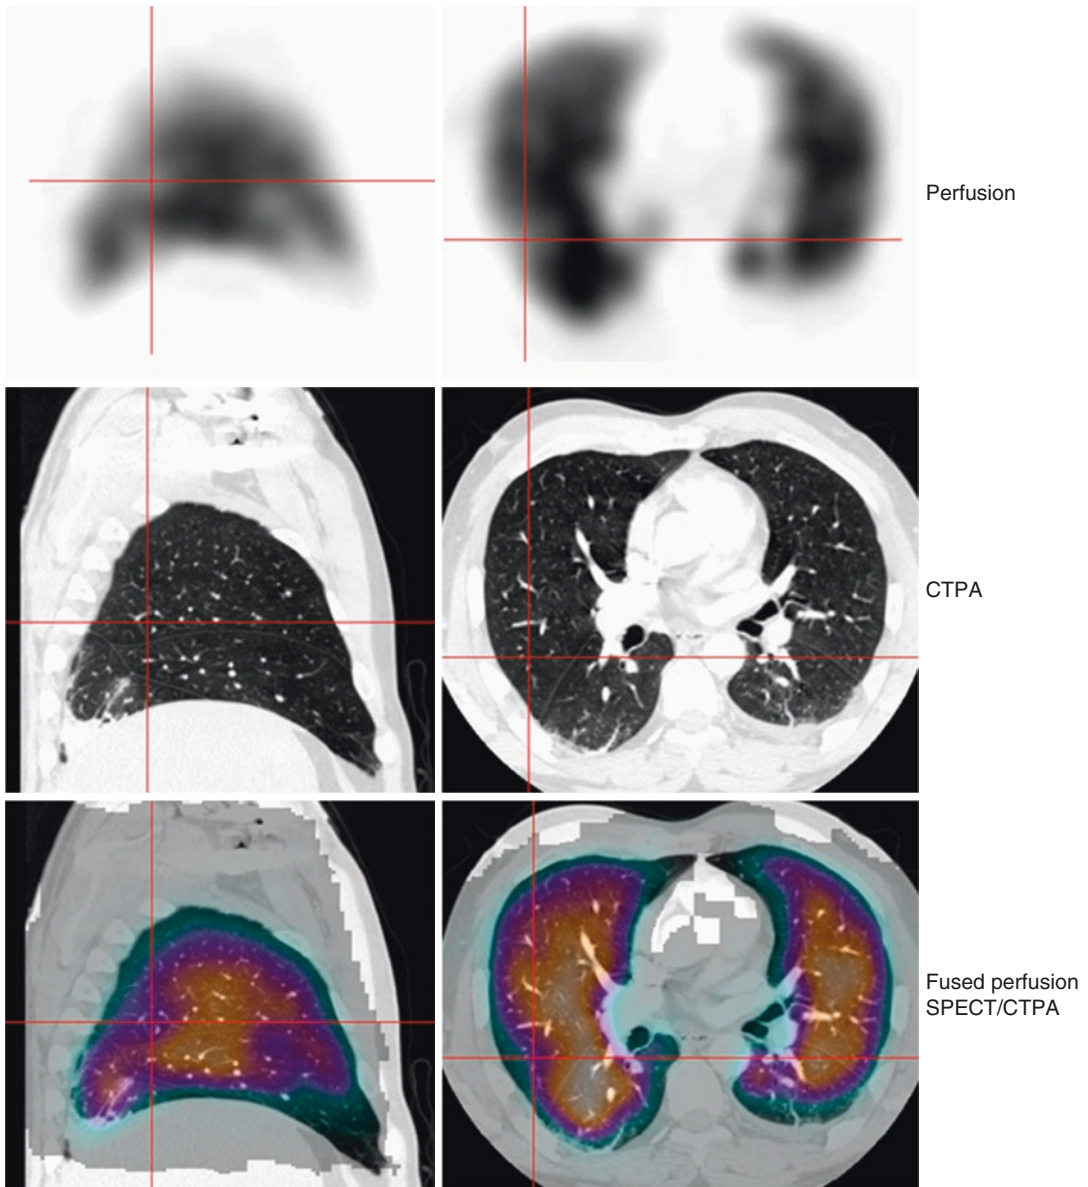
Sagittal and transaxial perfusion, CTPA and fused perfusion SPECT/CTPA slices in a patient with PE. Based on normal lung charts, the defect shown (*red cross hair*) was localised to the superior segment of the right lower lobe. The CTPA demonstrates volume loss in the lower lobe due to atelectasis. The oblique fissure is
